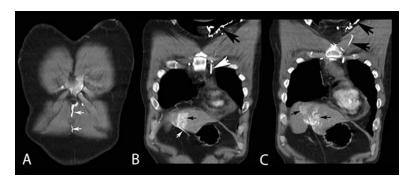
Coronal reconstructions of the contrast-enhanced portal venous phase CT images in Figs. 3 and 4, using 80mL Omnipaque 350 i.v. via the left upper extremity. The thin white arrows indicate the recanalized paraumbilical vein (A, B). There is hyperenhancement along the falciform ligament (thin black arrows, B, C). The thick black arrows indicate chest wall collaterals (B, C) and the thick white arrow indicates the internal thoracic vein (C).
